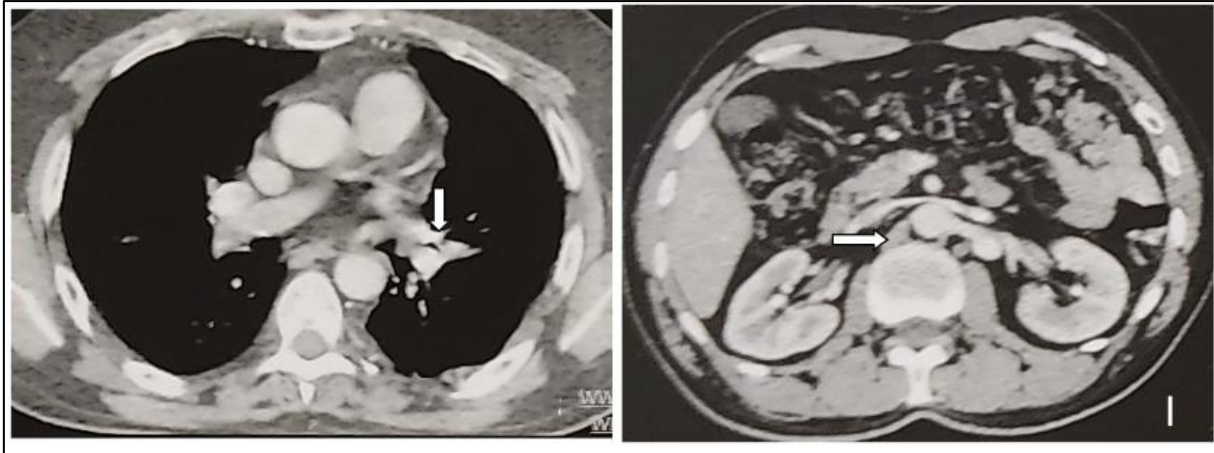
Thoracic (a) and abdominal (b) CT scans in axial section showing stabilization of mediastinal fibrosis and clear regression of retroperitoneal fibrosis with disappearance of the right ureterohydronephrosis
